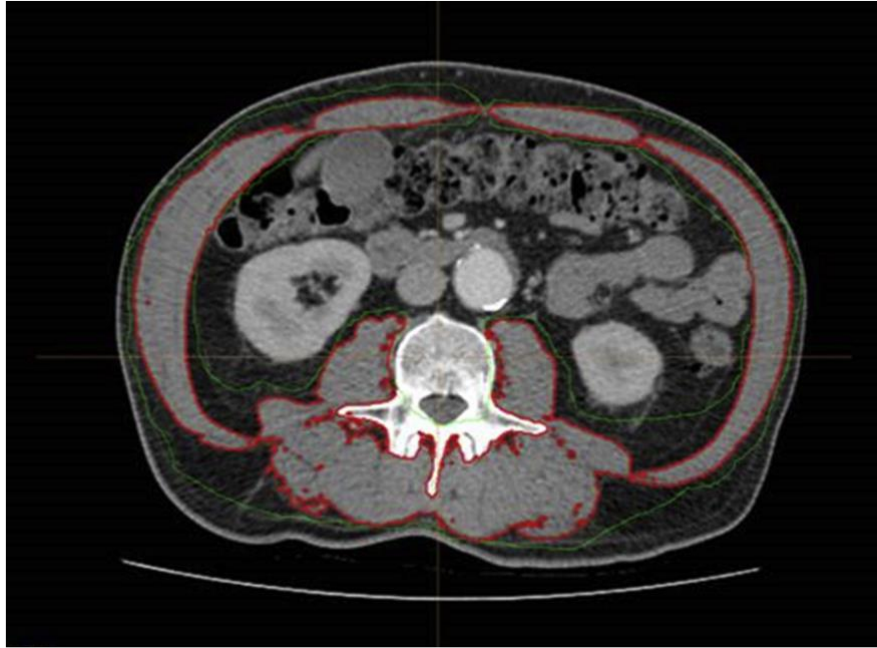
CT assessment of sarcopenia at the level of third lumbar vertebra. Adapted from Perthen et al. ¹⁹⁷. Skeletal muscle area is encircled by red colour.
